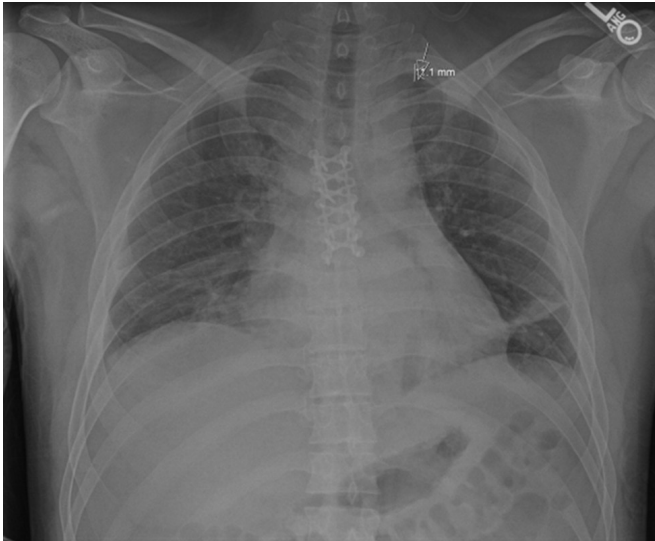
Postoperative chest radiograph showing plate placement and small left apical pneumothorax.
